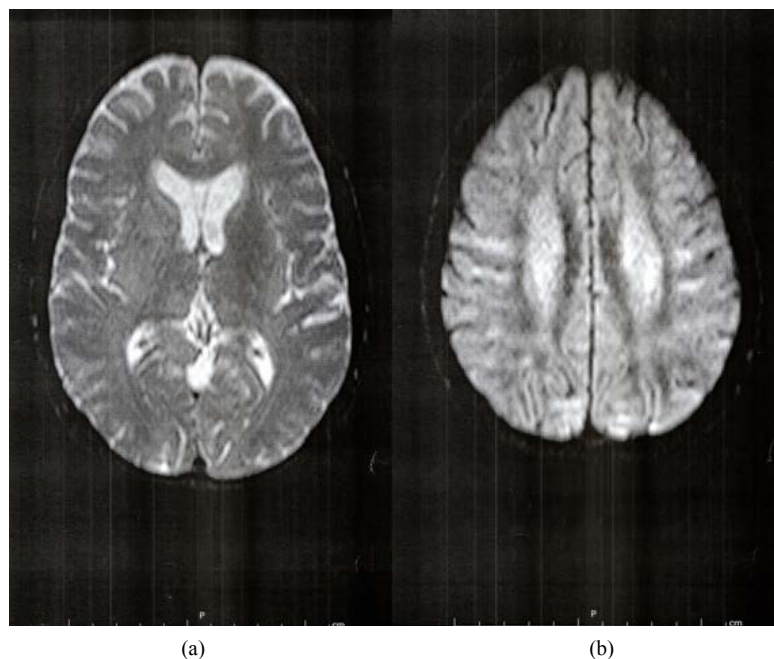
MRI brain with contrast showing T2/FLAIR hyper-intensity of white matter.
